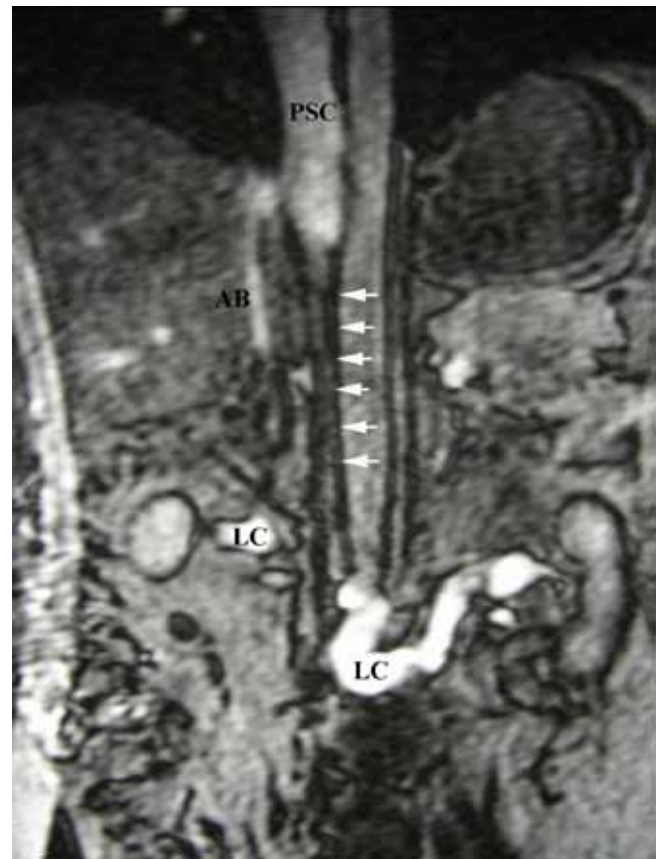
Coronal gradient echo MRI showing atresia of IVC between renal and hepatic segments (Sequential White Arrows) with a patent hepatic and suprahepatic IVC (PSC). Extensive, well developed collateralisation through ascending lumbar veins, azygous system and anterior abdominal wall subcutaneous veins (LC).
